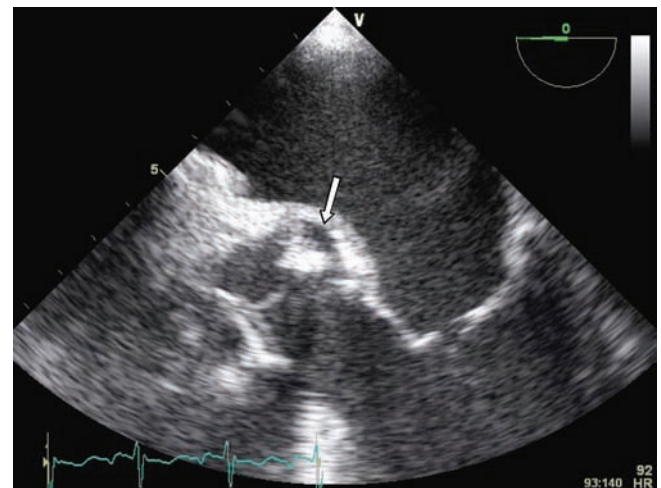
Transoesophageal echocardiography demonstrating an aortic root abscess posterior to the prosthetic aortic valve.
